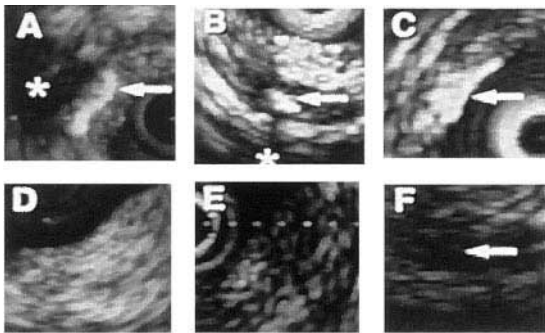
Tissue characterization by intravascular ultrasound imaging.
